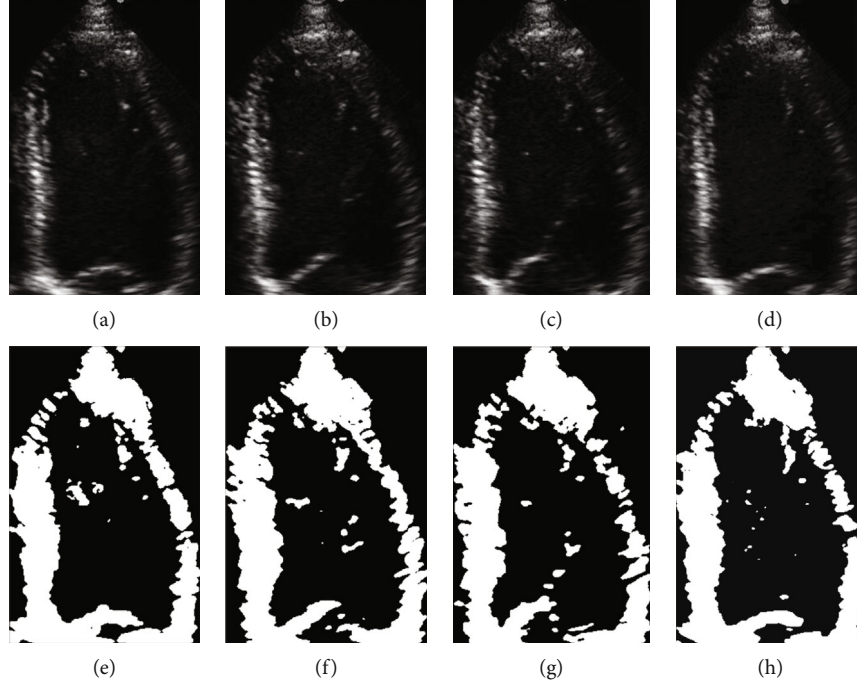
Binarization results of LV endocardium images based on MRF: (a–d) the original frames extracted at the equal interval from the same echocardiogram and (e–h) the corresponding binarization results.
